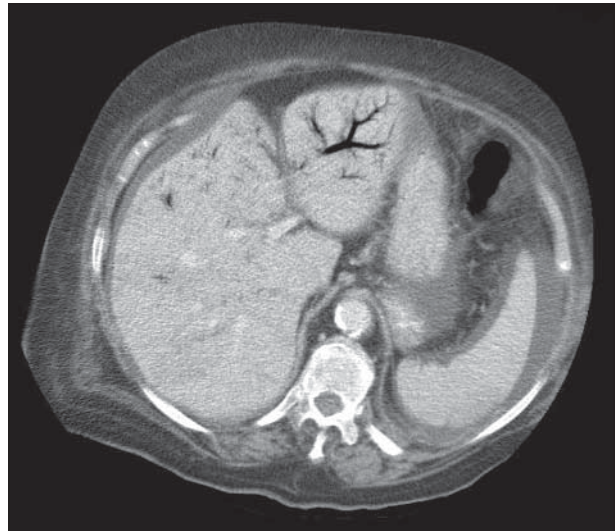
Abdominal computed tomography showing arborizing streaks of air in the liver.
